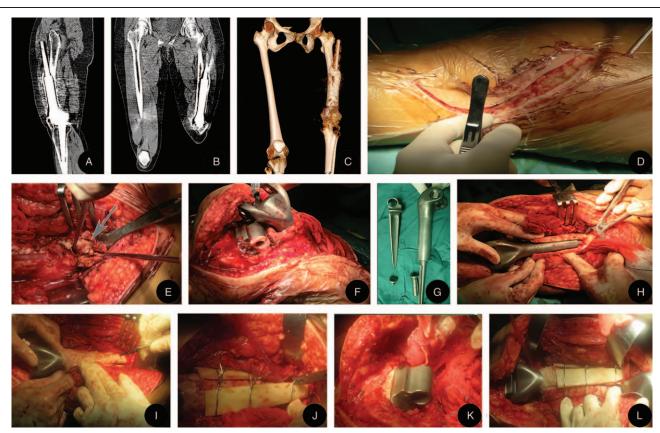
Computed tomography (CT) images of the left femur. Sagittal (A) and coronal (B) images as well as a reconstructed CT image (C) showing that the proximal part of the prosthesis penetrated the upper femur surrounded by a callus. There was no evidence of tumor recurrence. An intraoperative photo showing the incision was taken at the lateral femur starting from the small tuberosities and down to the lateral knee joint (D). The scars and proliferous bony fibrous tissue adjacent to the prosthesis were cleaned up (E). Then, we extracted the loosened prosthesis through proximal fenestration and distal reaming (F, G). Subsequently, the femoral marrow cavity was filled with bone cement and surface of the prosthesis was covered, followed by implantation of the distal prosthesis (H, I). Two allogeneic cortical bone plates were fastened to the bone defect of the anterior femur by 3 wires (J). Eventually, the prosthesis was successfully connected (K, L).
